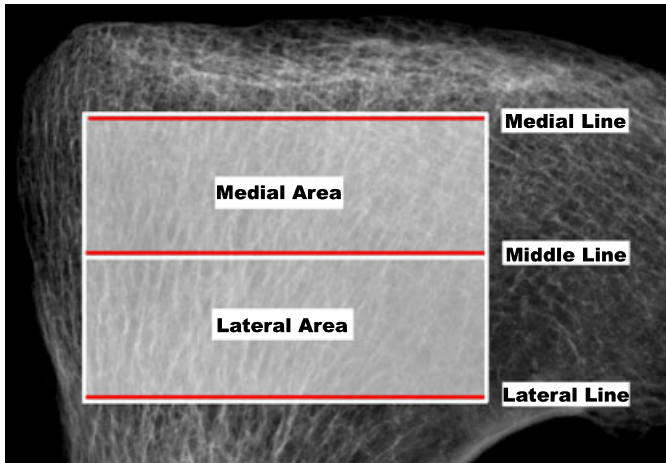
Lines and areas from which the plain film measures were drawn.
